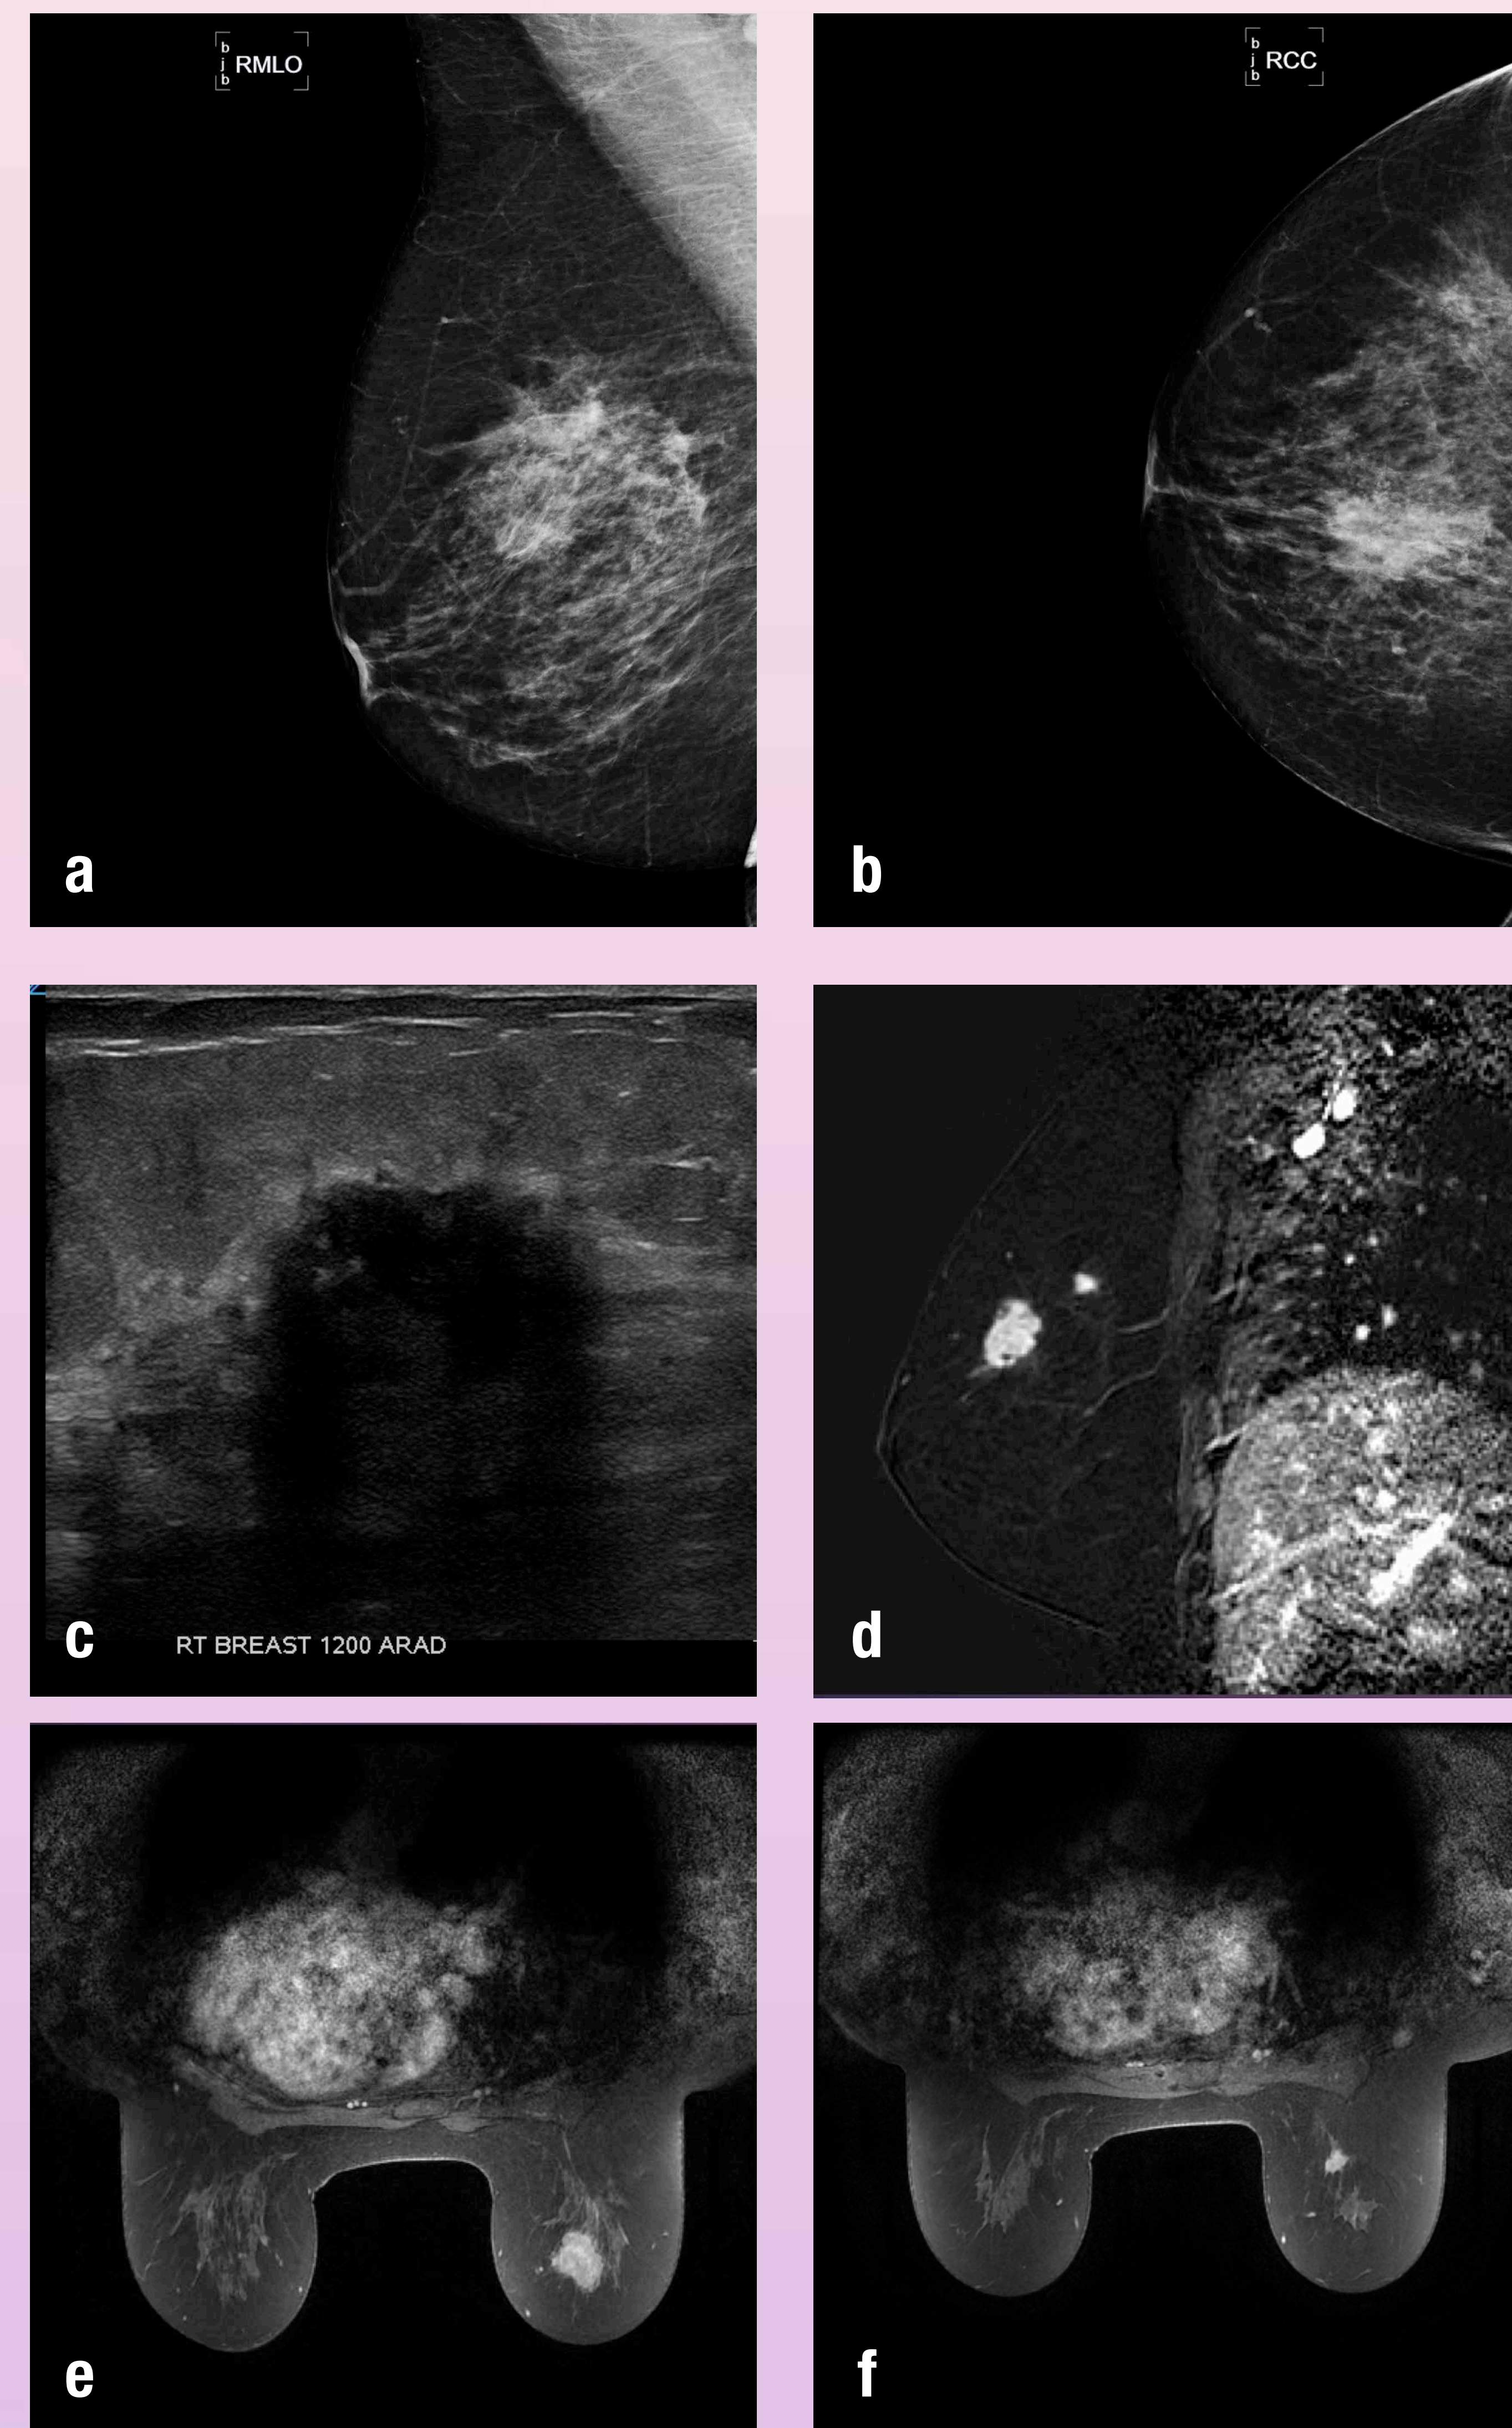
Detection of additional lesion on breast MRI.
